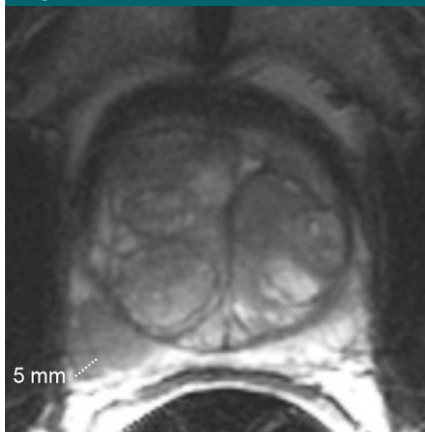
Clinical stage T2a, Gleason 4+3 prostate cancer and benign prostatic hyperplasia in 65-year-old man. Axial T2-weighted MR image (5000/96) shows 5 mm of extracapsular extension in the right posterior part of the midgland.
